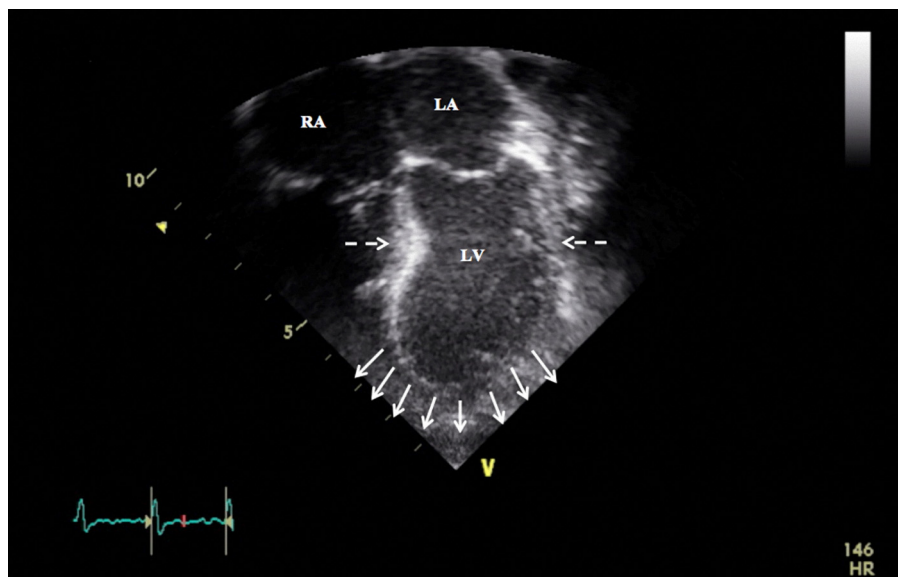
Four chamber echocardiographic view during systole. The dashed arrows point at the narrowing in the mid and basal segments of the left ventricle. The solid arrows represent left ventricular apical ballooning.
